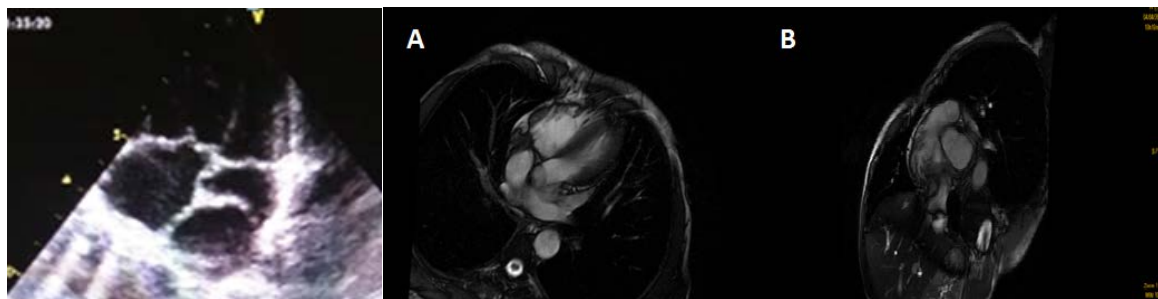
Transthoracic echocardiogram (apical 4-chamber view) shows a membranous structure subdividing the left atrium
